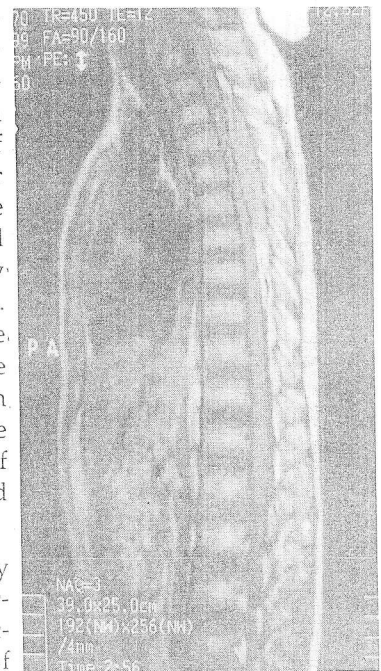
Un-enhanced T1-weighted MRI (sagittal view) showing a lesion at the upper dorsal spine causing cord compression from posterior. The lesion is isointense to the spinal cord.
